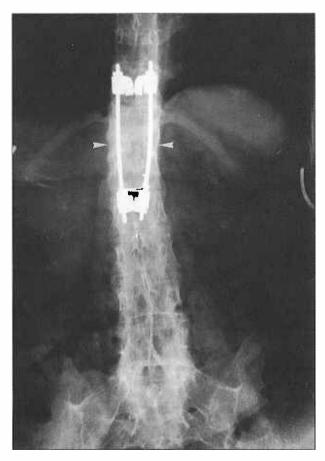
AP lumbar spine radiograph shows solid fusion at the thoracolumbar junction (arrowheads). Note bilateral Rochester compression rods.
